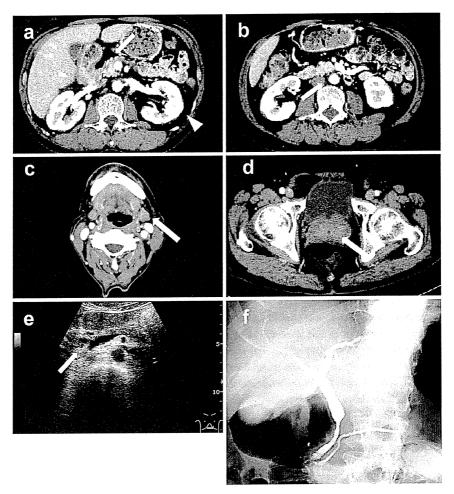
Imaging studies performed four weeks after the administration of prednisolone. CT showed marked decreases in pancreatic swelling (a, white arrow), the kidneys (a, white arrowhead), the retroperitoneal lesion (b, white arrow), the submandibular glands (c, white arrows) and the prostate (d, white arrow). The decrease in pancreatic swelling was marked on US (e, white arrow). ERCP revealed a marked decrease in the irregular surface pattern and narrowing of the pancreatic duct. The stricture of the common bile duct was not fully recovered four weeks after the administration of prednisolone (f).
